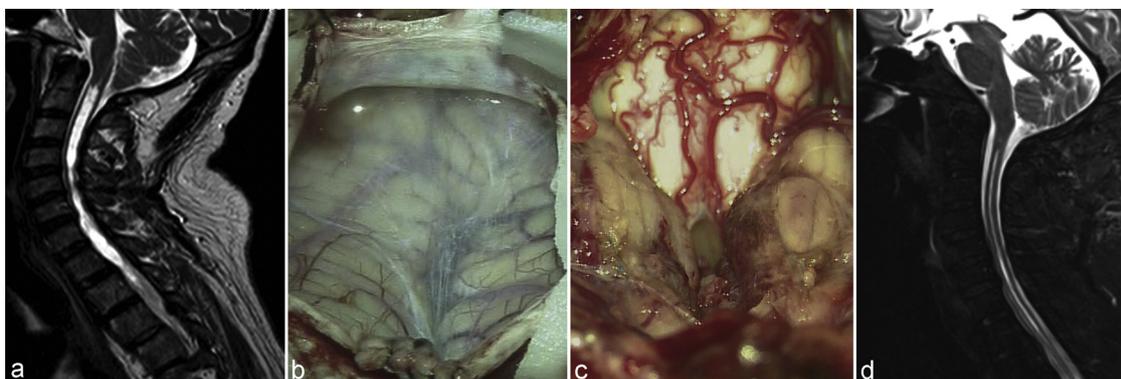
A 43-year-old female patient with a 2-year history of occipital pain. (a) T2-weighted MR scan of crano cervical junction revealed a classical CM-1 with a syrinx from C2 to T6. (b) After dura opening, no apparent arachnoid pathology was found. (c) Subarachnoid resection of bilateral tonsils and inspection of Magendie foramen. (d) Follow-up MRI examination 0.5 years after surgery revealed a wide cisterna magna with obvious resolution of syrinx. The symptom of occipital pain was vanished.
